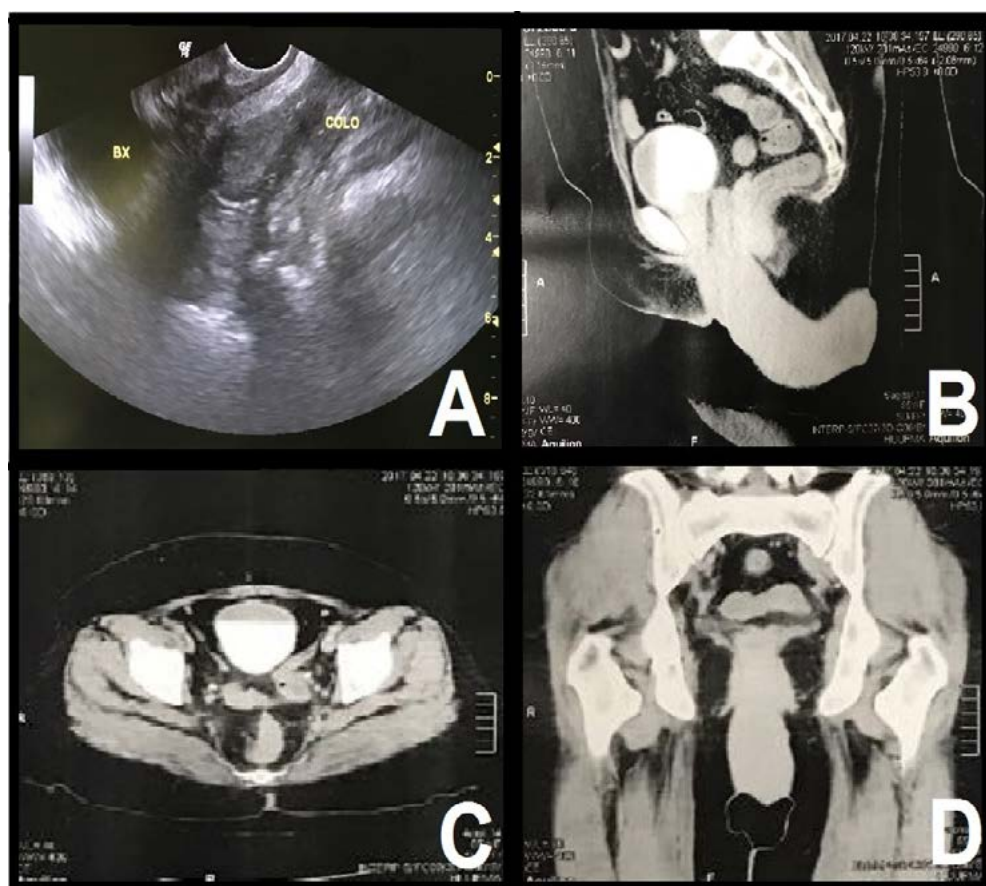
Imaging exams. A: TVUS with uterine myoma in uterine prolapse - B: Pelvic CT sagittal cut - C: Pelvic CT axial cut - D: Pelvic CT coronal cut. Vieira, GTB. São Luís - MA, 2018.
